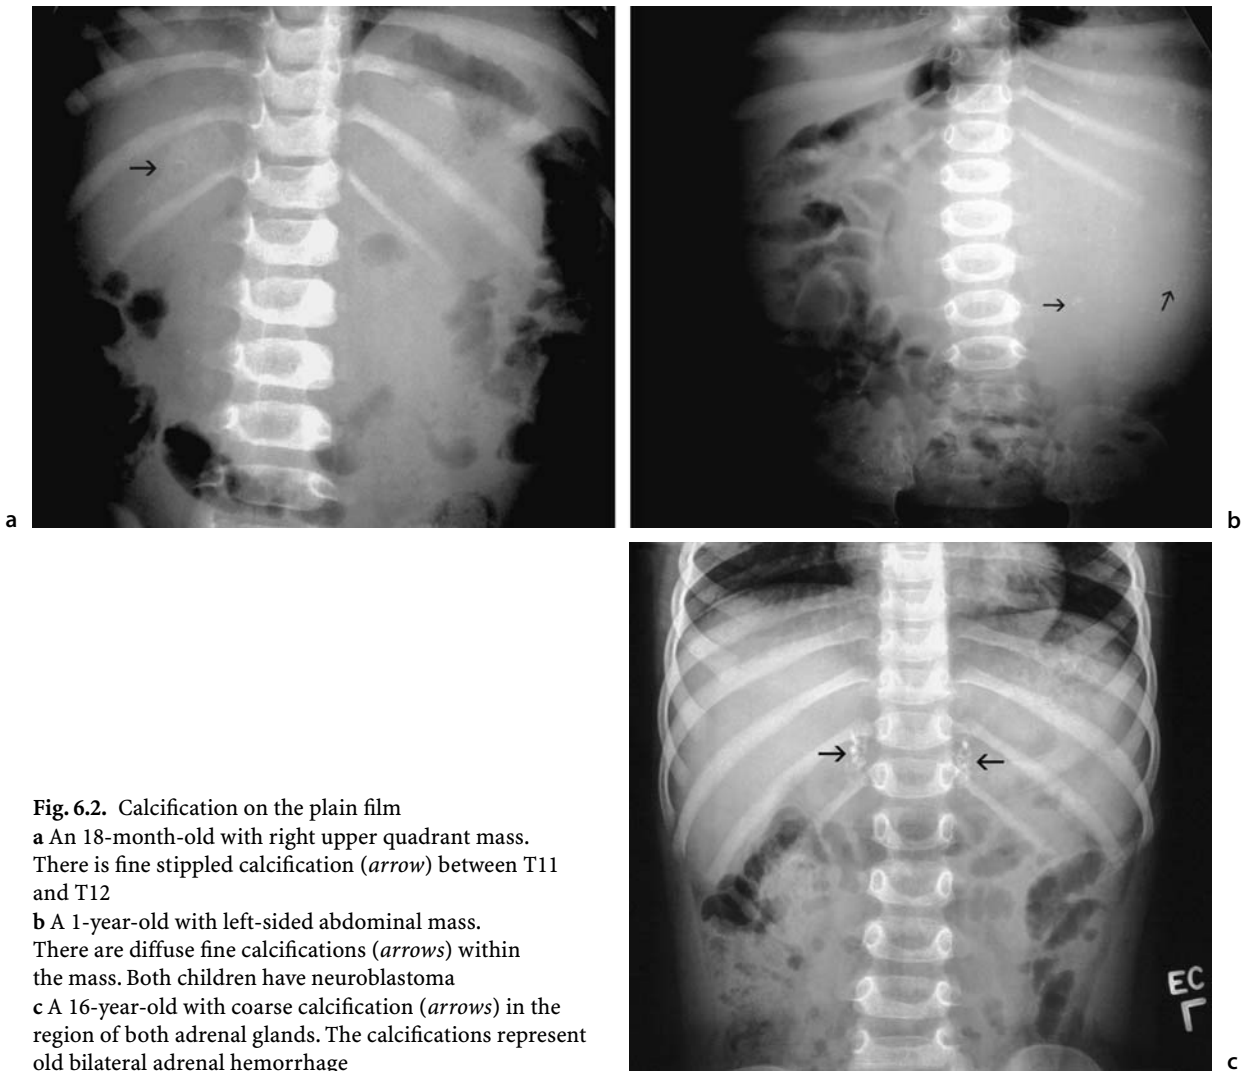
Calcification on the plain film
